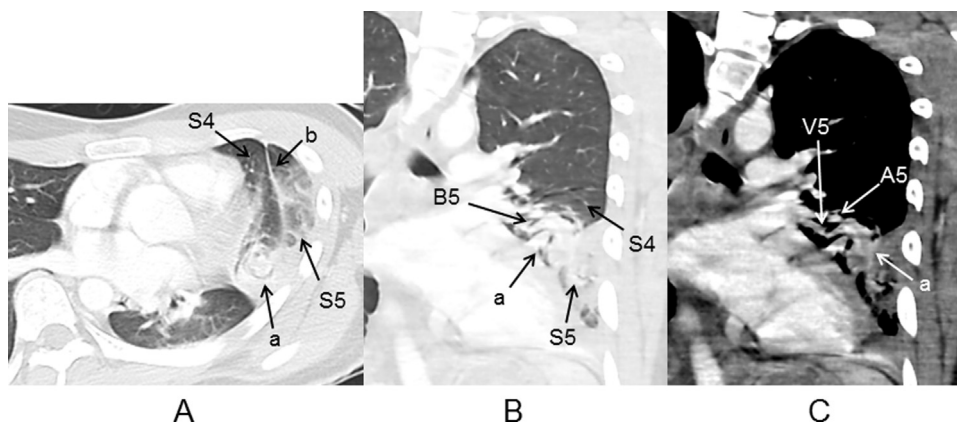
Chest contrast-enhanced CT showing a convoluted appearance (a) on the central side of S5 and consolidation on the peripheral side. There was a border with a linear structure (b) thought to be an accessory fissure between S4 and S5 (A). Bronchus, pulmonary artery, and vein of S5 became constricted, bent and rolled up to form a convoluted shadow (B, C).
